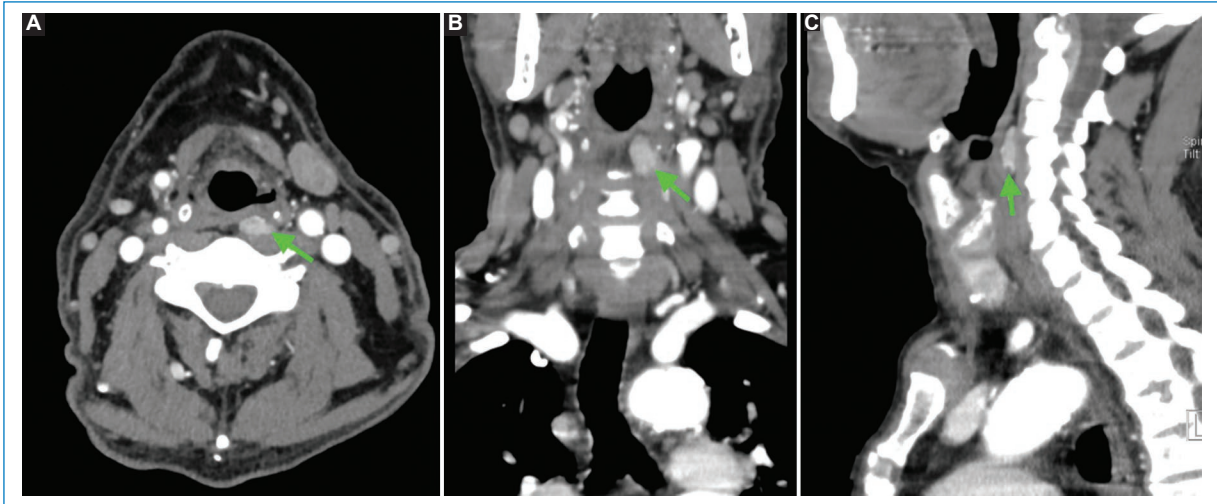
Axial (A), coronal (B), and sagittal (C) images from a 4D computed tomography scan of the parathyroid gland in the arterial phase, showing a left parasagittal nodular lesion in the retropharyngeal space at the level of the pyriform sinus, consistent with an ectopic parathyroid adenoma (arrows).
